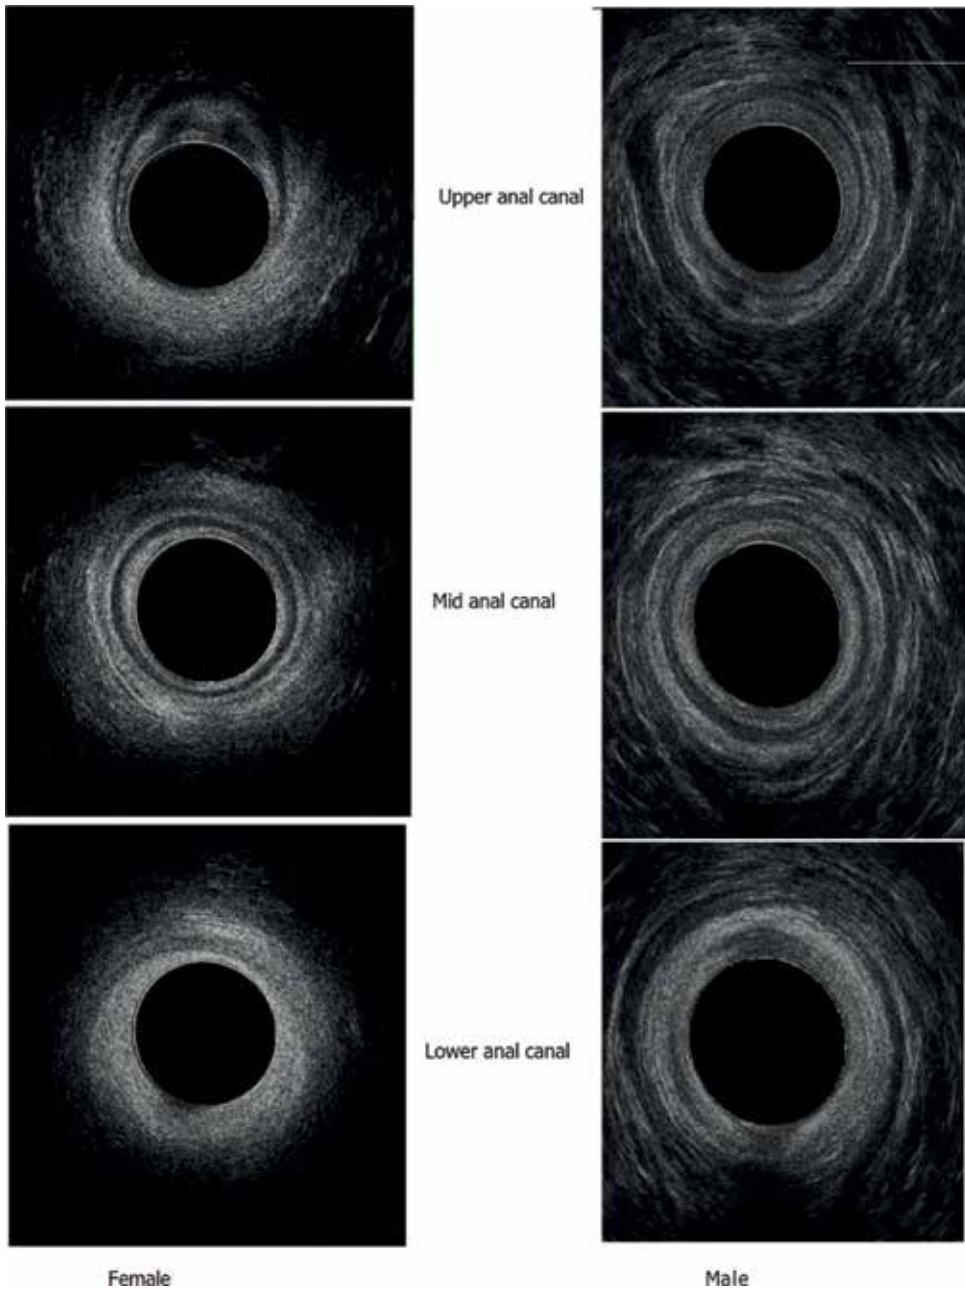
Normal endoanal ultrasonographic views of anal canal at three levels—left: in female and right: in male.
